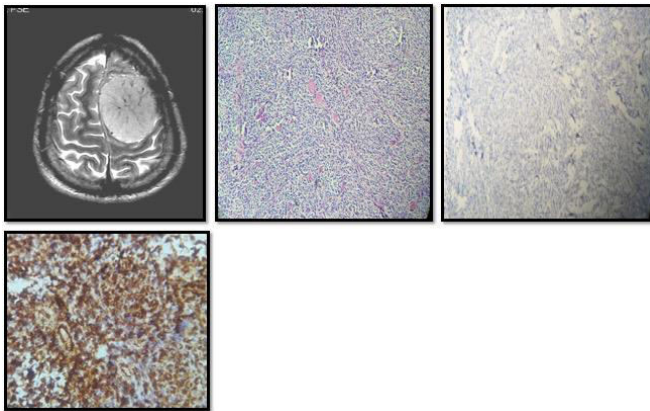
Meningioma A)MRI showing Fronto-parietal space occupying lesion B) H& E Section shows tumours cells in whorls and sheets C) On IHC : Tumor cells negative for GFAP D)On IHC: Tumor cells positive for Vimentin
